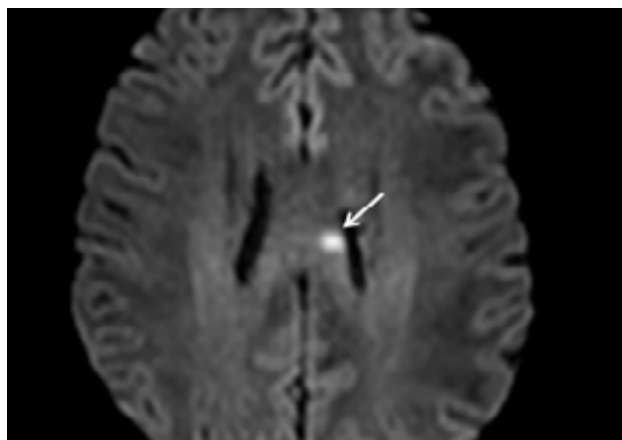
MRI of a 36-year-old woman presenting with ataxia, dysarthria, cranial neuropathy, and cerebellar dysfunction. Axial diffusion-weighted imaging sequence showing a focus of restricted diffusion, consistent with cytotoxic edema, in the corpus callosum (arrow).
